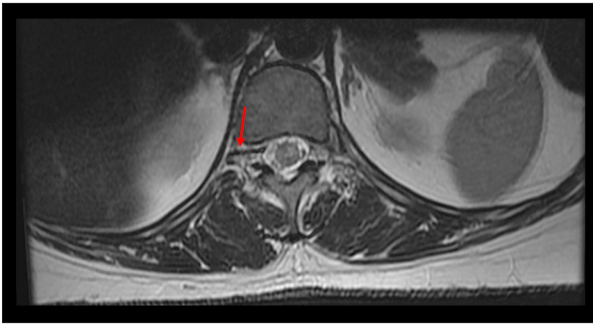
Axial T2-weighted MRI image confirming the presence of an ill-defined intramedullary conus lesion with prominent enlarged epidural veins (arrow) and a vertebral venous plexus.
